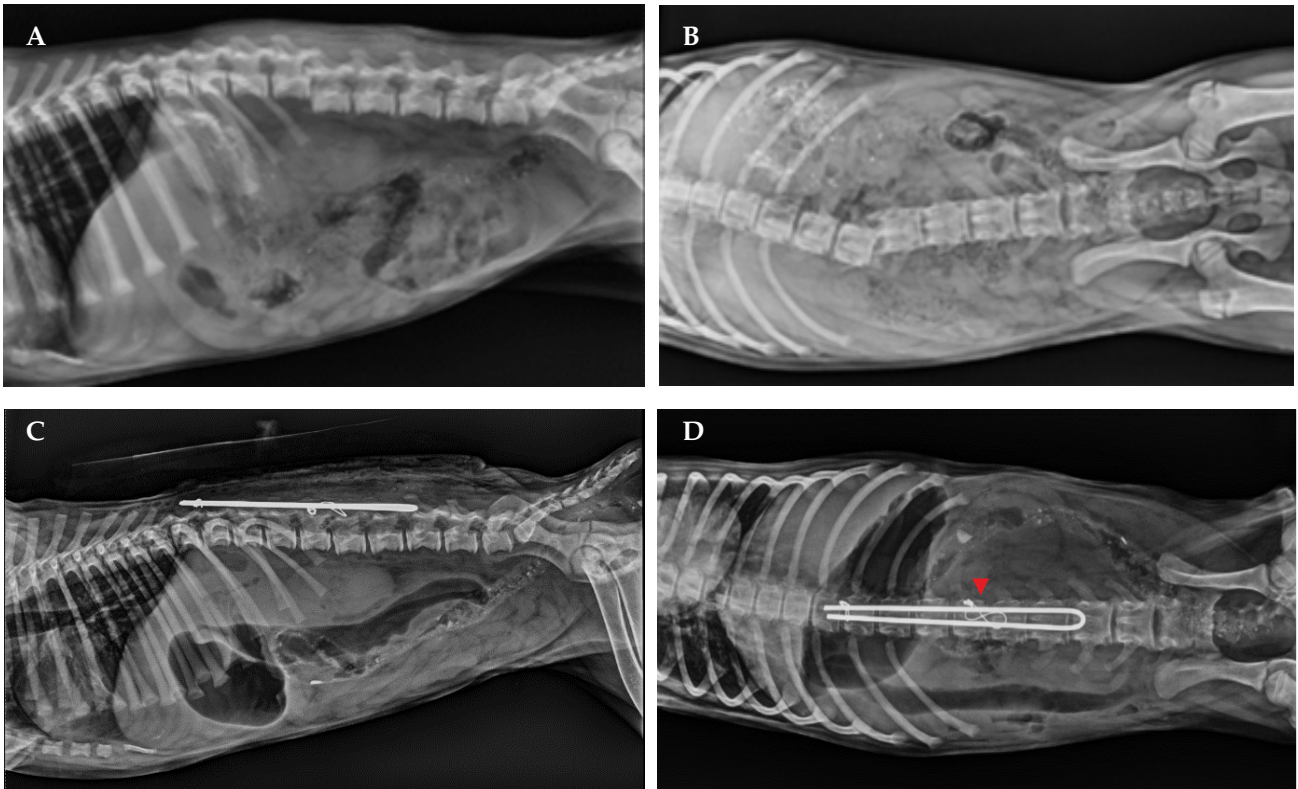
Preoperative lateral (A) and ventro-dorsal (B) radiographic projections in the demonstrate fracture and luxation of the L2-L3 joint; postoperative lateral (C) and ventro-dorsal (D) viewsshowing stabilization with tension band wiring and spinal stapling technique. Notice the reduction and alignment achieved in the fractured vertebral segments (red arrow).
